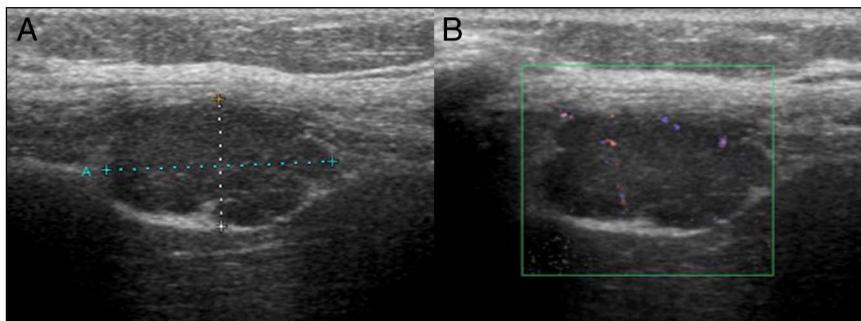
(A) Ultrasonography revealed a 24.8 × 14.0-mm tumor between the abdominal wall and the surface of liver segment 5. (B) Color Doppler ultrasonography showed blood flow in the tumor.
